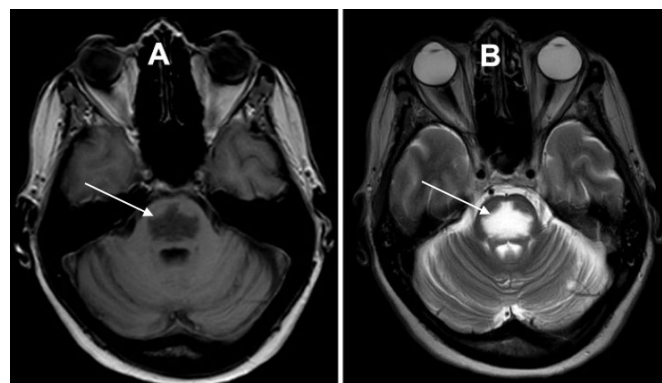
(A) T1 and (B) T2 brain MRI performed five weeks after symptom onset showing respectively marked hypointense and hyperintense changes to the central pons (arrows) measuring 2.3×1.5 cm and indicating a region of severe axonal destruction as a result of ODS.
